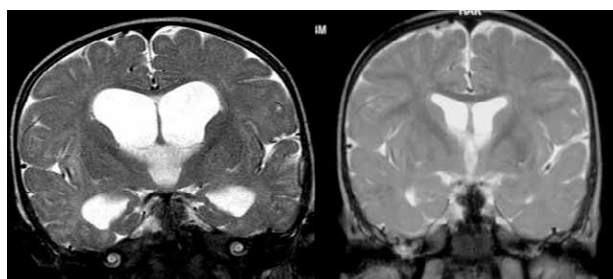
Noncommunicating hydrocephalus in a 8-months old girl (left preoperative MRI; right postoperative MRI).
